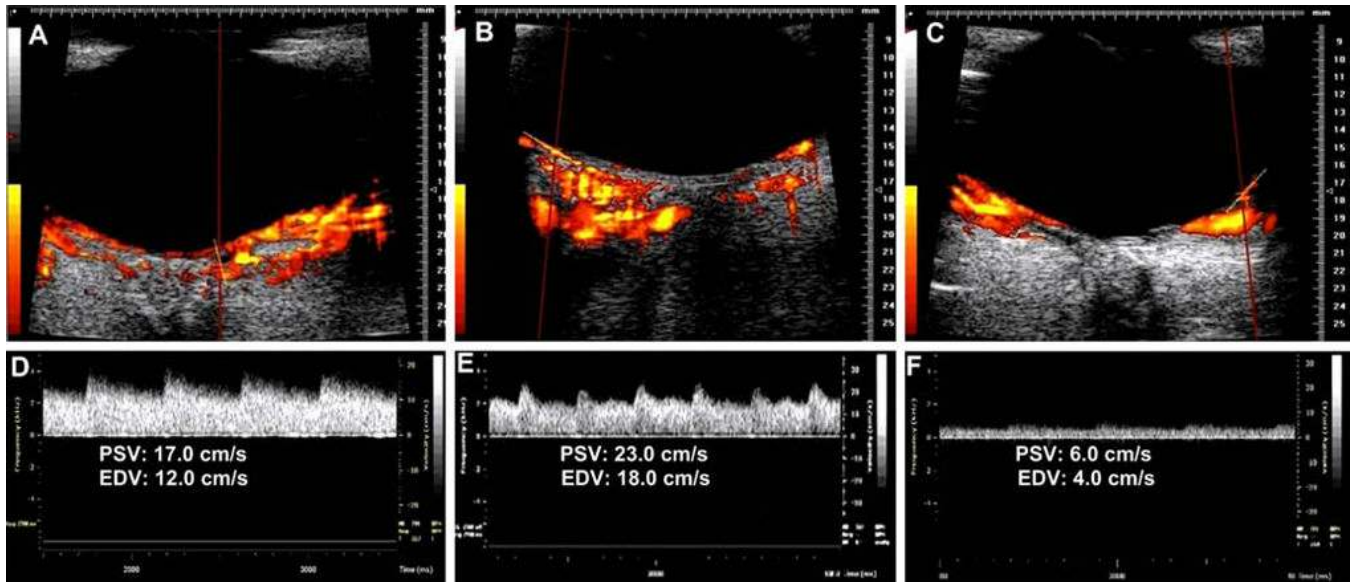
Combined power Doppler and spectral Doppler imaging of a long posterior ciliary artery (a, d), CRA (b, e), and the branch retinal artery (c, f). Blood velocity in the artery is represented by peak systolic velocity (PSV) and end diastolic velocity (EDV)
